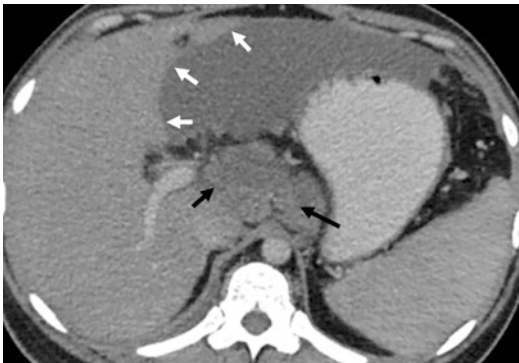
Serohepatic tuberculosis. Axial contrast-enhanced CT image shows a large subcapsular hypodense collection indenting and “scalloping” the left lobe of liver (white arrows). There are bulky, necrotic, conglomerated gastrohepatic, and retroperitoneal lymphadenopathy extending along the subcapsular plane (black arrows). (Courtesy of Dr. Jansi Sekar, Naruvi Hospital, Vellore, India)
